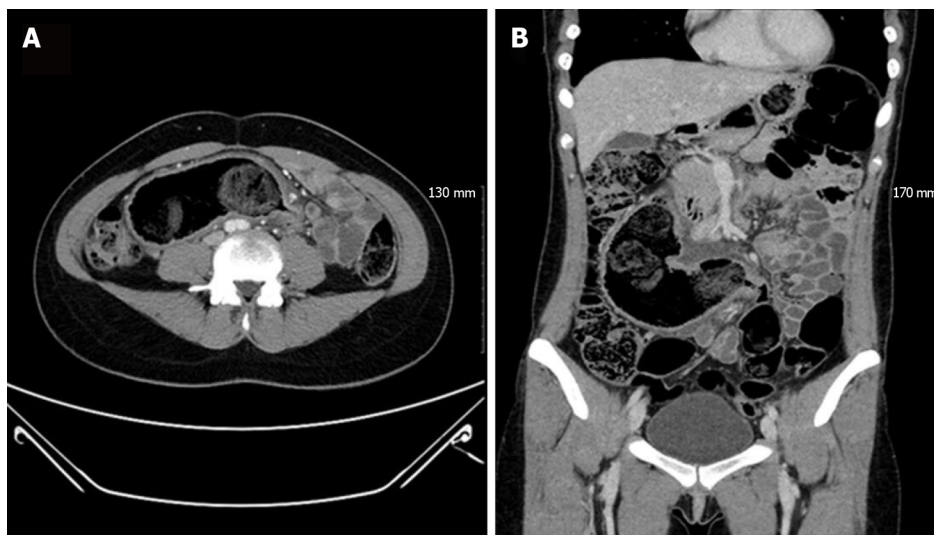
Abdomino-pelvic computed tomography showed a blind, dilated bowel loop filled with fecal material, directed to right upper quadrant of abdomen. A: Axial view; B: Coronal view.
